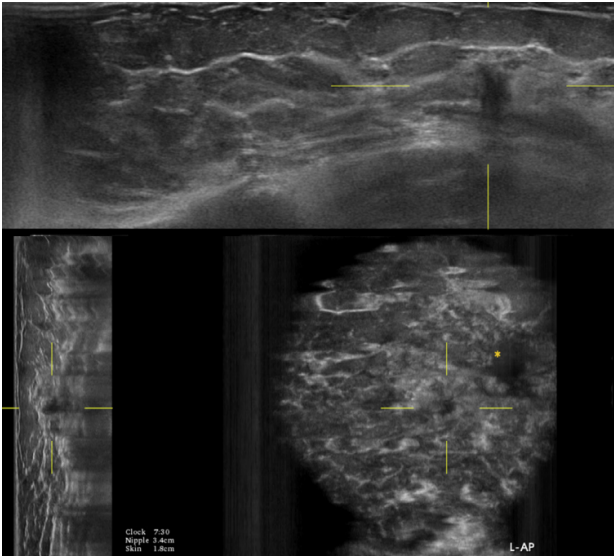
An example of a lesion in orthogonal planes of an automated 3D breast ultrasound volume [54].
